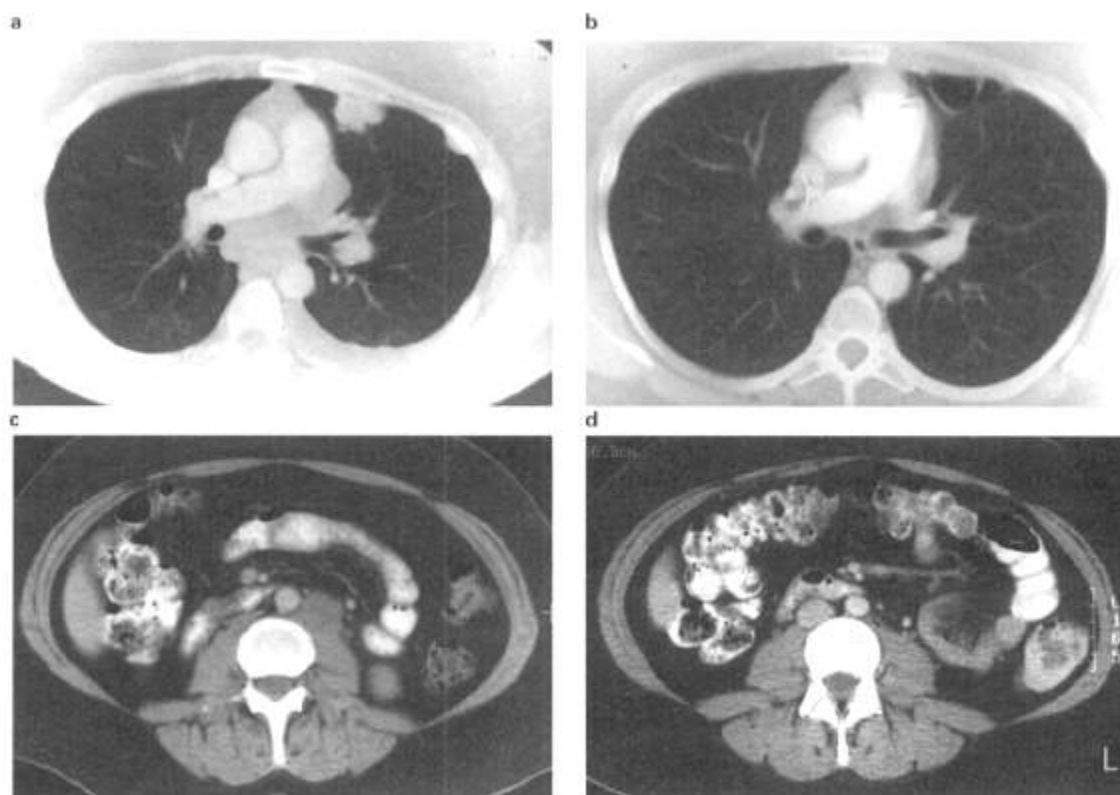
(a) CT of the lung and mediastinum showed mass in the left upper lobe subcarinal adenopathy and left pleural effusion. (b) Post-treatment CT of the lung and mediastinum showed complete regression of the mass in the left upper lobe and subcarinal adenopathy and complete resolution of pleural effusion. (c) Pre-treatment CT of the abdomen at the lower para-aortic level showed a 3 cm left para-aortic adenopathy. (d) Post-treatment CT at a similar level showed complete regression of the adenopathy.
